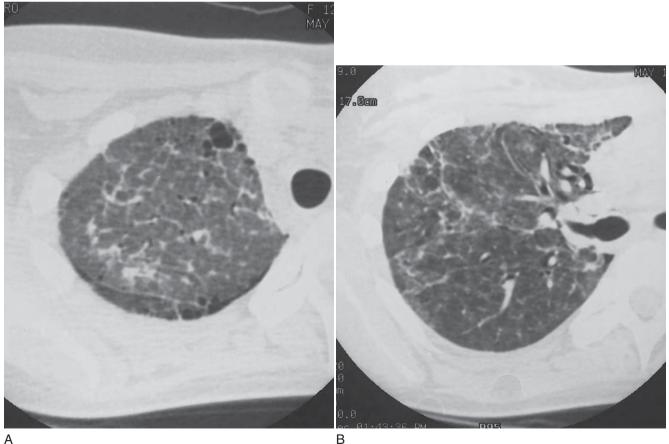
Ulcerative colitis patient with diffuse peribronchial thickening suggesting bronchiectasis (A). High-resolution CT scan confirms the presence of bronchiectasis and quantitates the extent of disease (B). Bronchiectasis typically develops after colectomy.
